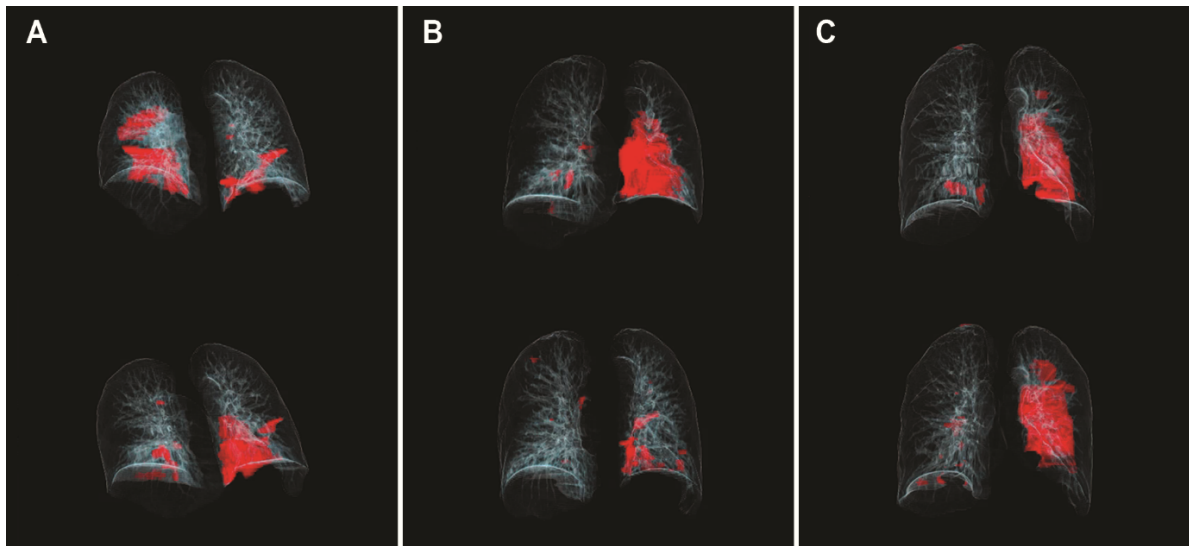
Volume Rendering reproduced from Siemens Syngo.via software CT. Analysis of three subjects: A, B, C, before (top) and after (bottom) treatment. The segmented lung opacities are shown in red. Subject A: left lung OS before treatment = 1; OS after treatment = 2; right lung OS before treatment = 2; OS after treatment = 1; considering both lungs, OS variation = 0 (Stability). Subject B: left lung OS before treatment = 4; OS after treatment = 1, right lung OS before treatment = 0; OS after treatment 0; considering both lungs, OS variation = -3 (improvement). Subject C: left lung OS before treatment = 3; OS after treatment = 4; right lung OS before treatment = 1; OS after treatment = 0. Considering both lungs, OS variation = +1 (worsening).
